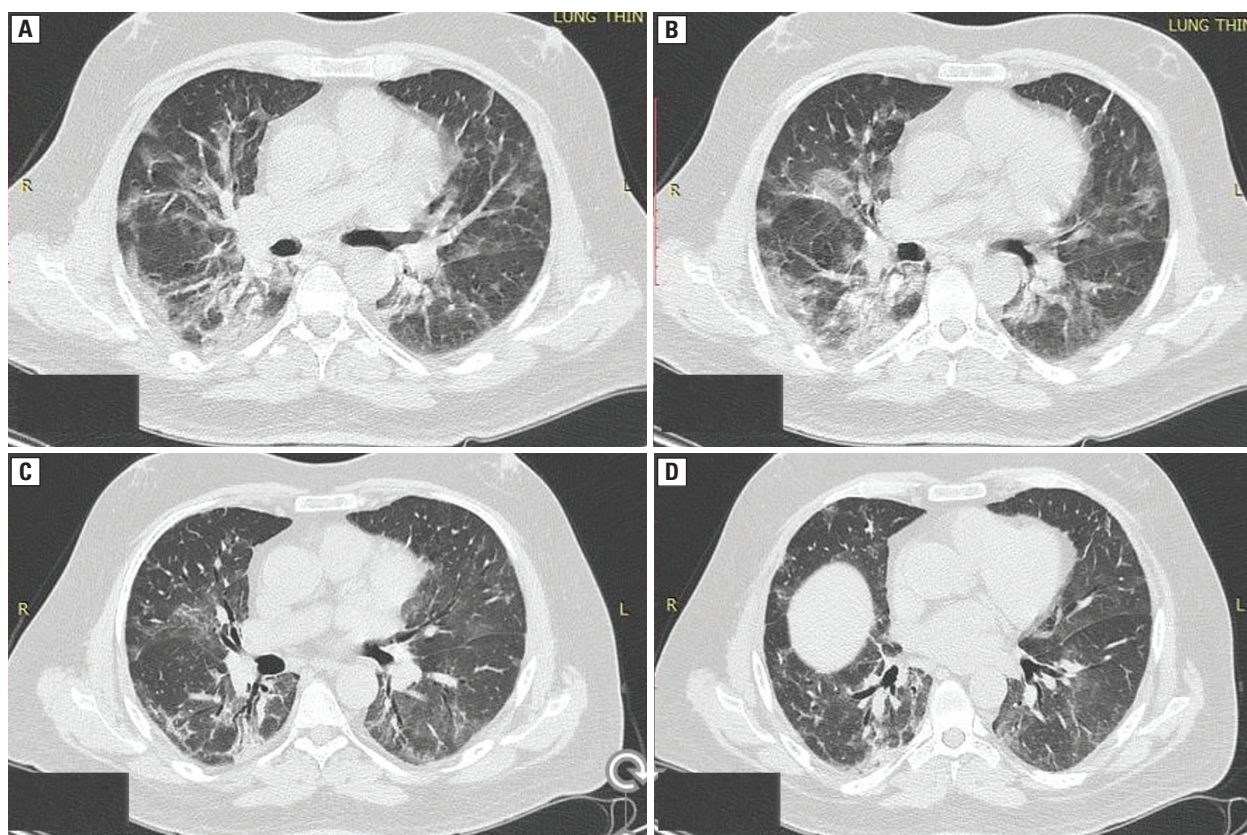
High resolution computed tomography of chest showing bilateral consolidation with traction bronchiectasis; C, D. High resolution computed tomography of chest showing clearing of fibrotic opacities after 4 weeks of nintedanib
